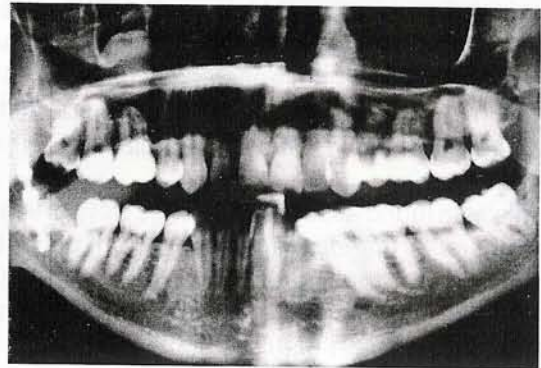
Transbuccal Approach; Final X-ray
